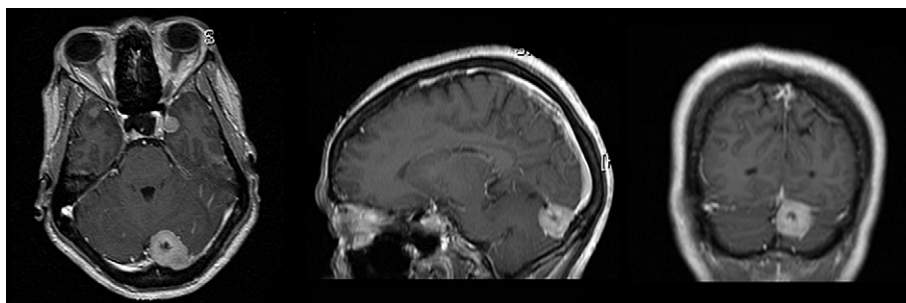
T1-weighted cerebral MRI showing a well-defined occlusion-causing meningioma, intensely enhanced after intravenous gadolinium injection, next to the left transverse sinus and confluence of the sinuses (left to right: axial, sagittal and coronal).
